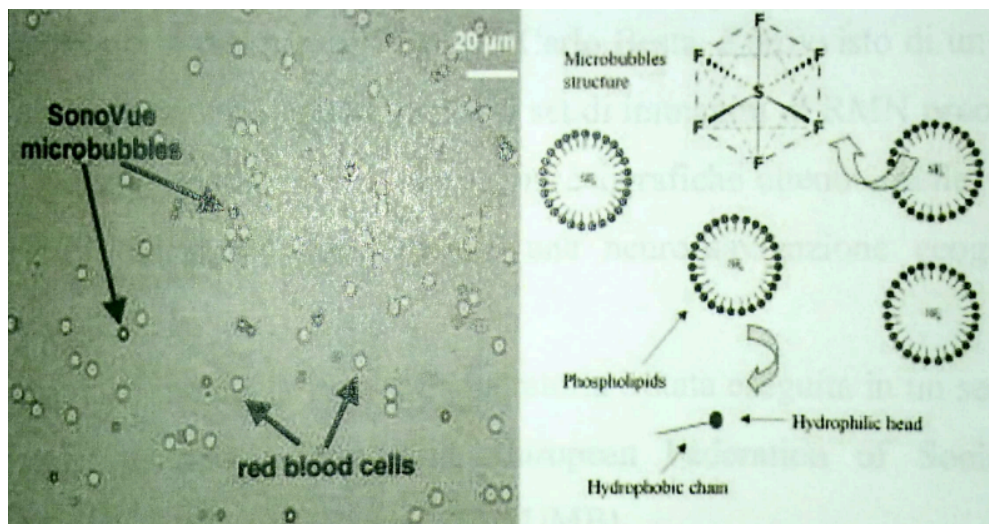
Ultrasound contrast medium
